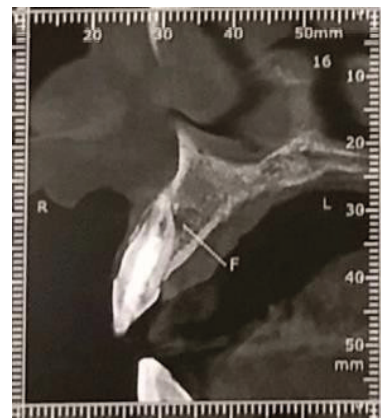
Sagittal volumetric computed tomography image showing the periapical lesion.
